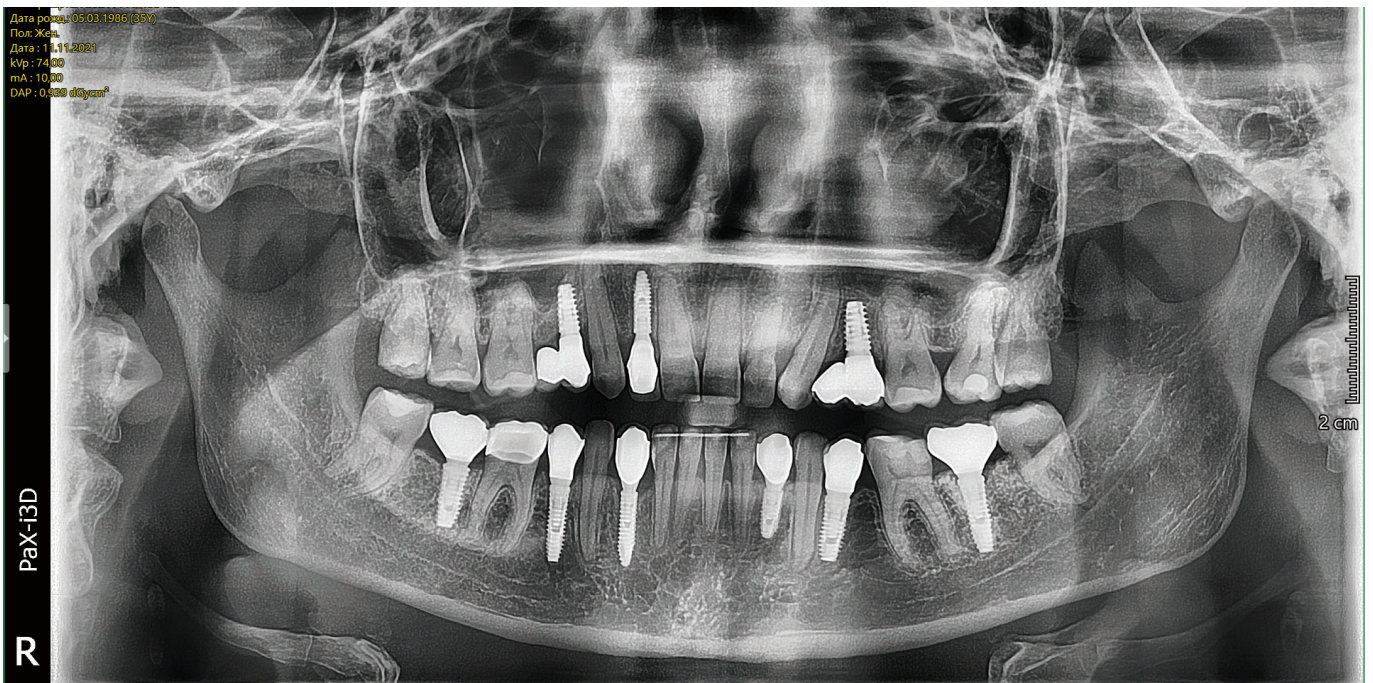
Panoramic x-ray after treatment
